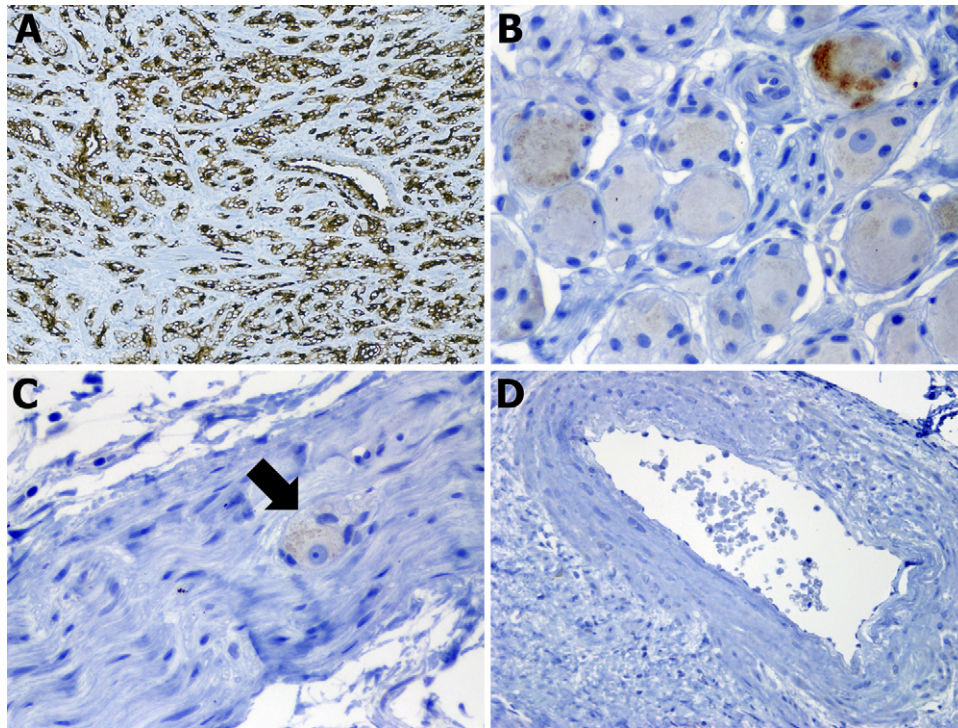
Patterns of PSMA expression. (A) Prostatic adenocarcinoma, Gleason score 3+4=7, with strong and diffuse PSMA immunorexpression in tumor cells. (B) Ganglionic cells showing focal, weak cytoplasmic PSMA expression. (C) Peripheral nerve sheath cells negative for PSMA expression; note the ganglionic cell (arrow) with weak cytoplasmic PSMA positivity. (D) Vascular element negative for PSMA expression. (Color version of figure is available online.)
